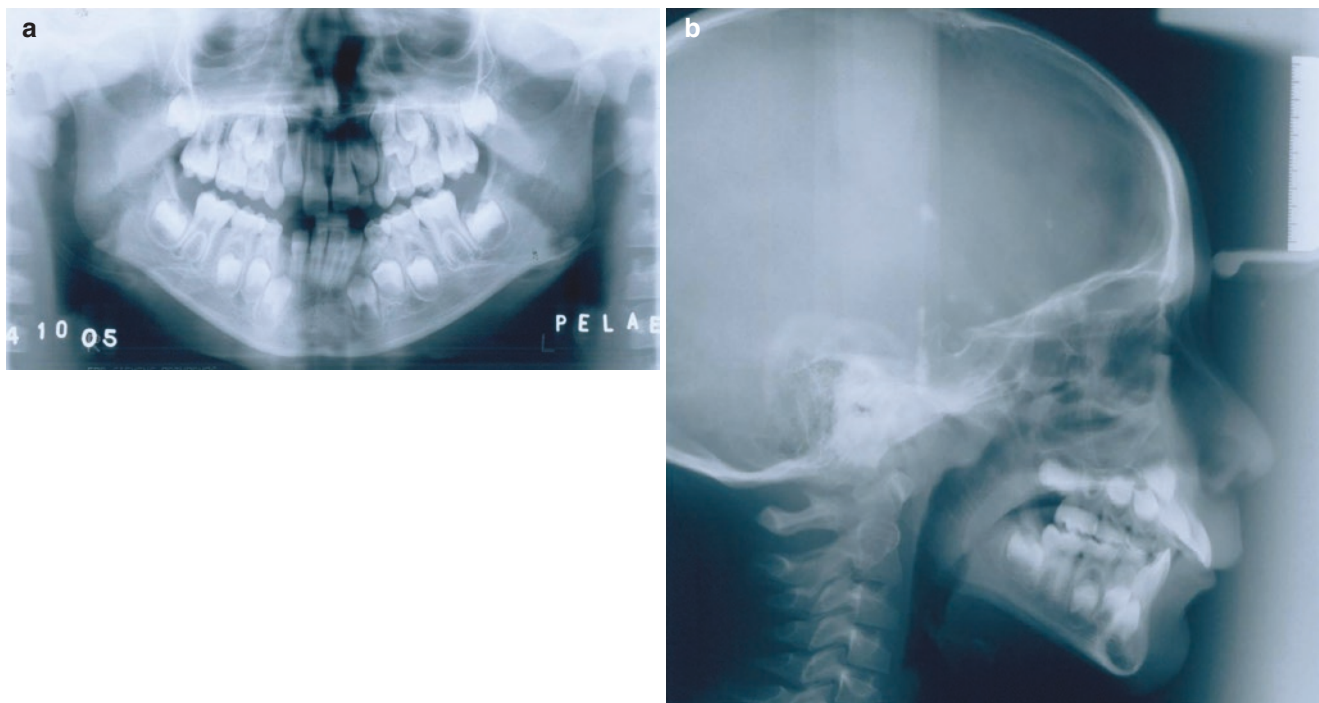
(a, b) Pre-treatment panoramic and lateral radiograph. The anterior position of the upper incisors was confirmed
